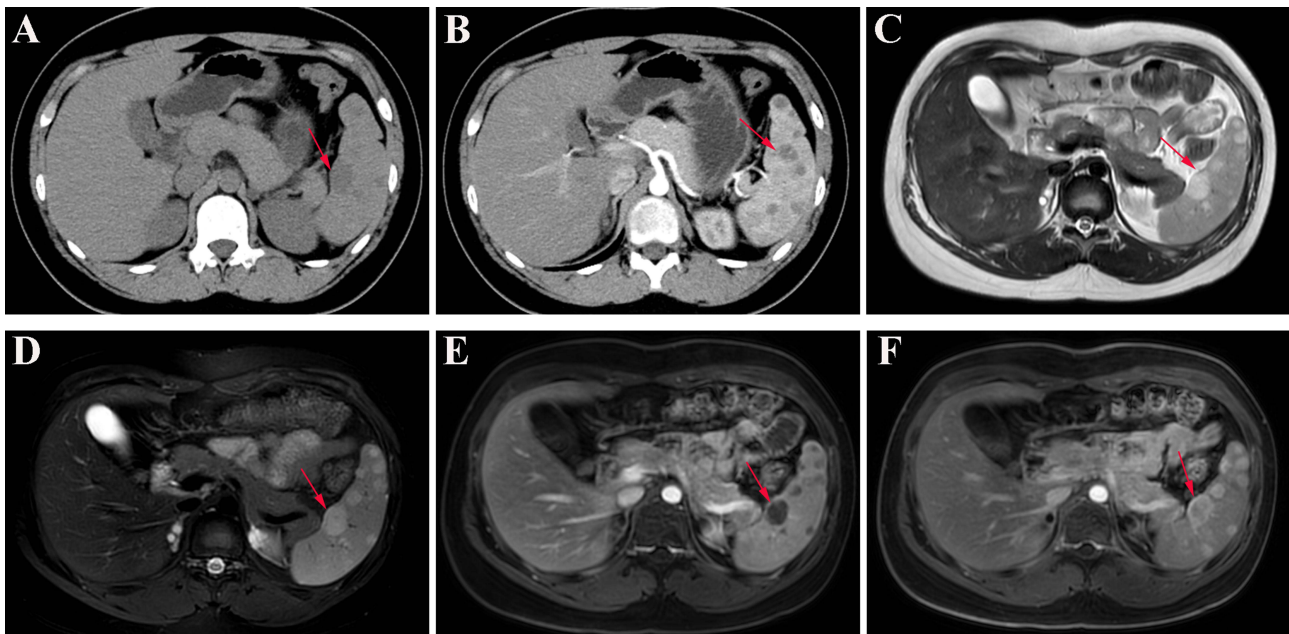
The imaging examinations of the patient. (A and B) Abdominal CT revealed multiple round or oval low-density lesions in the spleen (A), showing progressive enhancement during the contrast-enhanced phase (B). (C–F) MRI revealed multiple slightly hyperintense signals on both T1- (C) and T2-weighted (D) images in the spleen; Contrast-enhanced MRI demonstrated mild ring-shaped enhancement during the arterial phase (E), with delayed-phase enhancement surpassing that of normal splenic tissue (F). The lesions are indicated by the red arrows.
